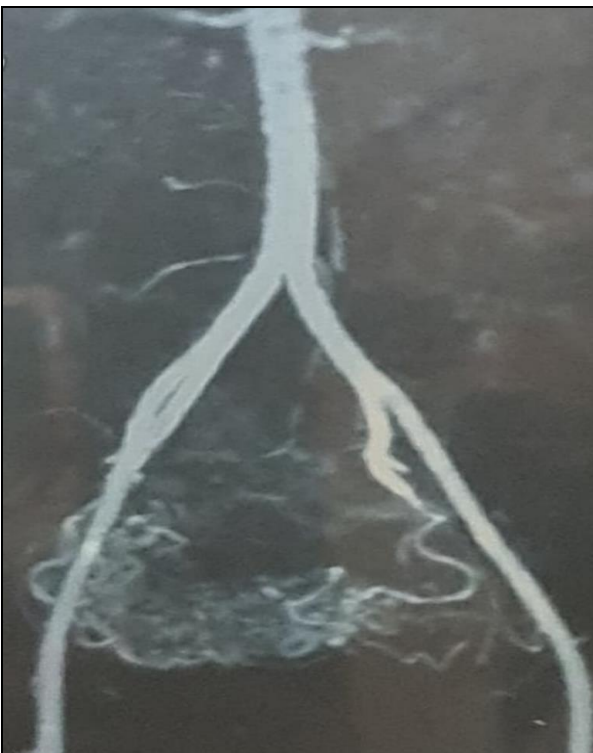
MRI angiography showing AV Malformation
